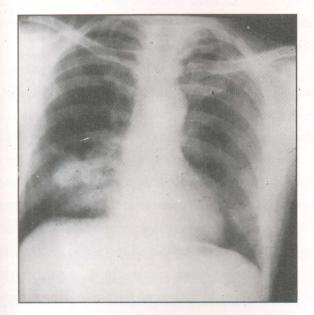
X-ray chest showing opacity in mid zone of right lung.
